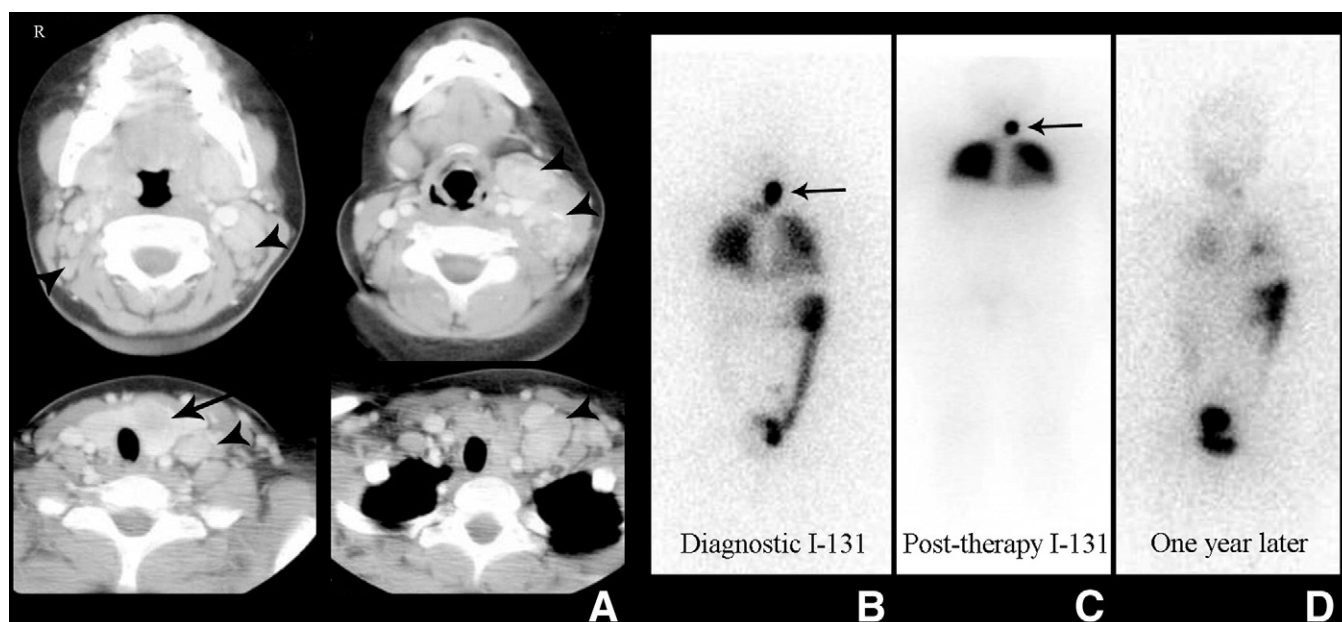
(A) Axial CT scans of a 12-year-old patient with “neck mass” reveals a low attenuation lesion in the left lobe of the thyroid (arrow) associated with bilateral cervical and supraclavicular lymphadenopathy (arrowheads). (B) Anterior whole body image from a I-131 scan obtained 12 weeks post total thyroidectomy and lymph node dissection for metastatic papillary thyroid carcinoma demonstrates residual uptake in large thyroid remnant or nodal conglomerate (arrow) in the left neck as well as diffuse lung metastases. These findings are better visualized on scan (C) obtained 10 days following treatment with an empiric dose of 200 mCi (7.4 GBq) of I-131, adjusted for patient weight/body surface area and age. Response to treatment is confirmed on anterior image from I-131 study performed 1 year later (D).
